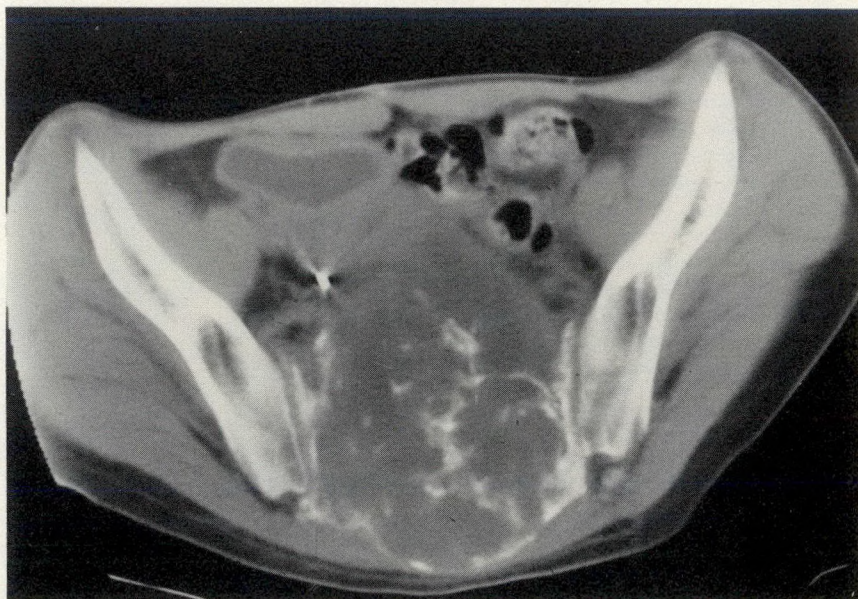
Computed tomogram through pelvis at level of sacroiliac joints 8 months after presentation shows increase in size of sacral mass anteriorly that had been noted in December 1986. However, there has been regression of posterior extension of tumour. There is also increase in calcification within tumour.
